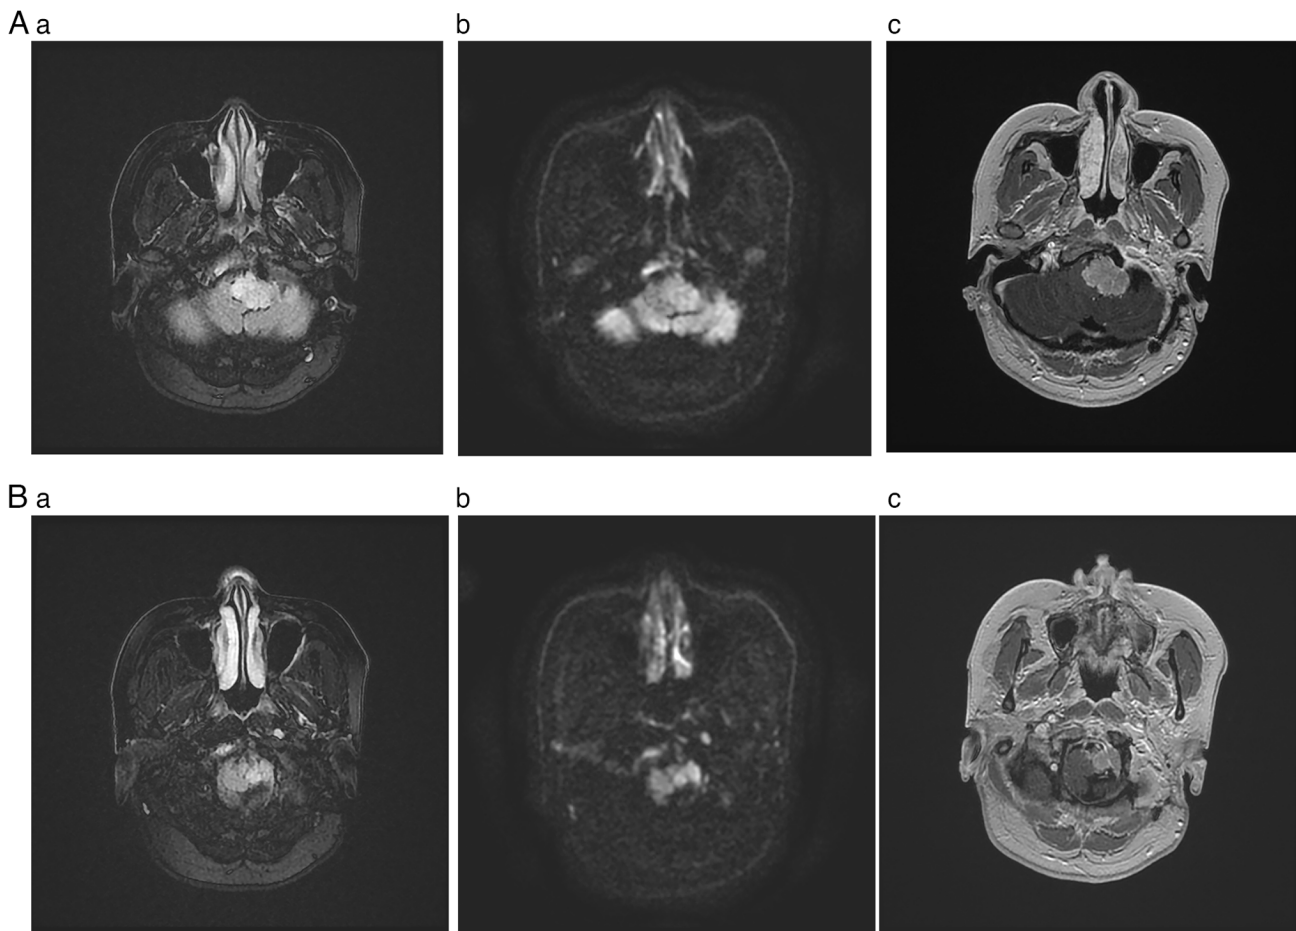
MRI study before treatment. (A-a and B-a) T2-weighted fluid-attenuated inversion recovery sequences showing a mass-like, marginally hyperintense signal involving the left jugular bulb region and the left lateral medulla oblongata. (A-b and B-b) Diffusion-weighted imaging revealing isointense or somewhat hyperintense signaling of the lesion in the same areas. (A-c and B-c) T1-weighted imaging displaying heterogeneous, mild-to-moderate contrast enhancement of the lesion at same sites. (A) and (B) represent different axial section levels of the same MRI sequence. MRI, magnetic resonance imaging.
